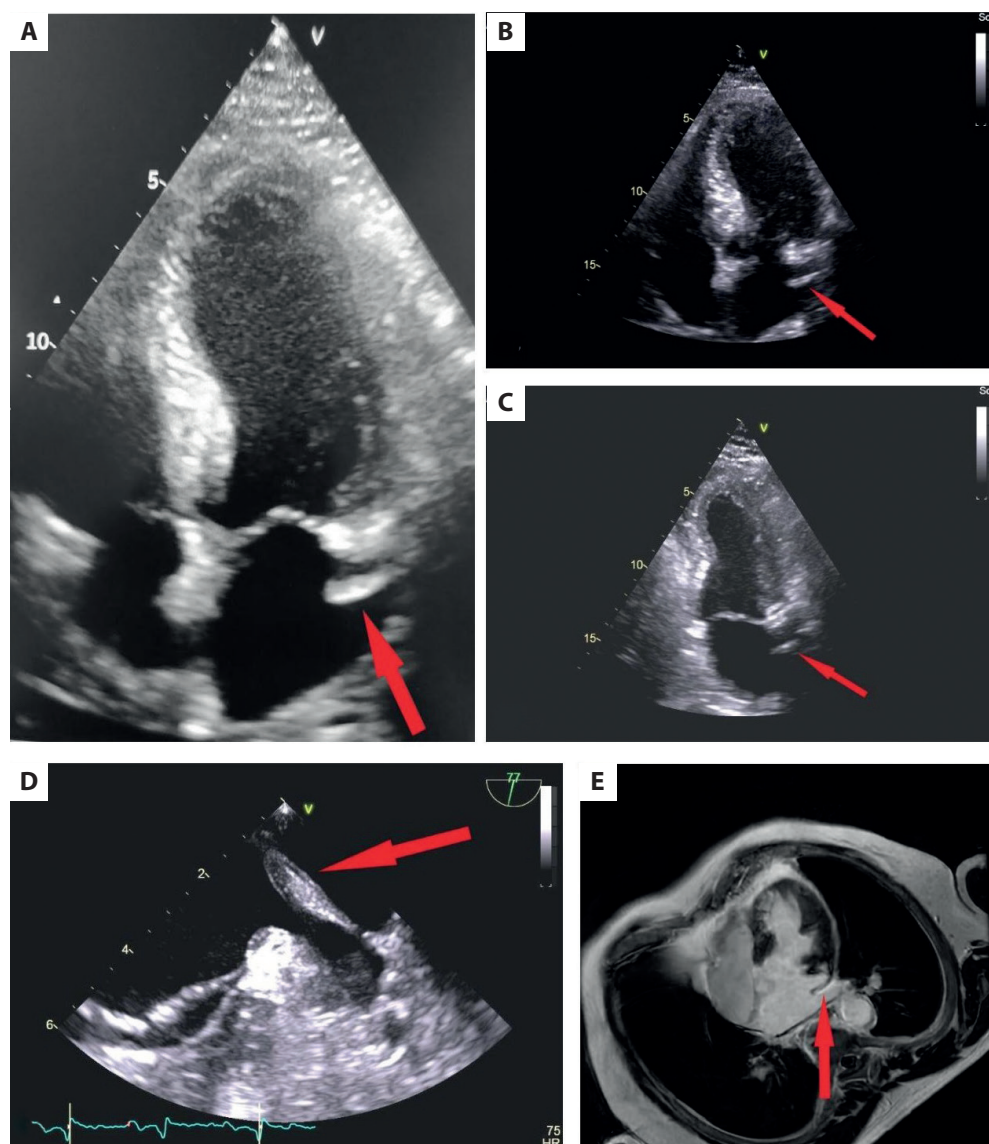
A. A focal lesion in the left atrium measuring 19×5 mm (apical four-chamber view) first noticed on bedside transthoracic echocardiography in a cardiac intensive care unit patient (red arrow). B. The coumadin ridge-like focal lesion in the left atrium (apical four-chamber view) visualized on repeat transthoracic echocardiography performed in the local echocardiography laboratory (red arrow). C. The coumadin ridge-like focal lesion in the left atrium (two-chamber view) visualized on repeat transthoracic echocardiography performed in the local echocardiography laboratory (red arrow). D. The location and structure of the coumadin ridge-like lesion measuring approximately 28 mm on transesophageal echocardiography (modified bi-commissural view) (red arrow). E. The coumadin ridge-like lesion in the left atrium on cardiac magnetic resonance imaging (red arrow)
